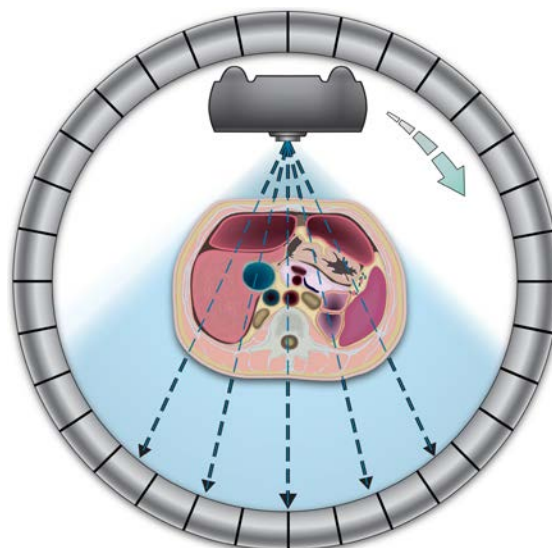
Fourth-generation CT scanner detector configuration.
